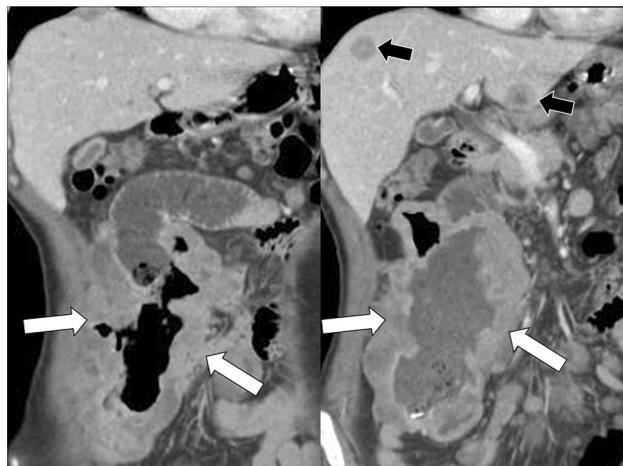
A 54-year-old man with abdominal discomfort. Coronal CT images show a huge mass with cavitary change mimicking annular wall thickening plus aneurysmal dilatation in the jejunum (arrows). Neither lymph node enlargement nor bowel obstruction was found on CT. Note two small hypoattenuated metastases in the liver (black arrows, right). After jejunal mass excision, the diagnosis of high-risk GIST was made
